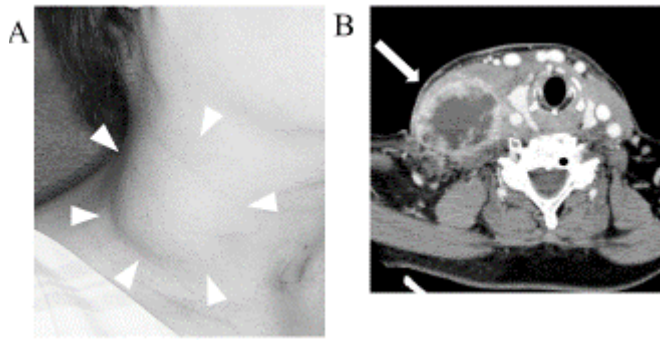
A large mass on the right side of the neck (A, arrow-head). Enhanced computed tomography image showing a ring-enhancing mass measuring 60x51 mm in the neck, level III on the right (B, arrow).
